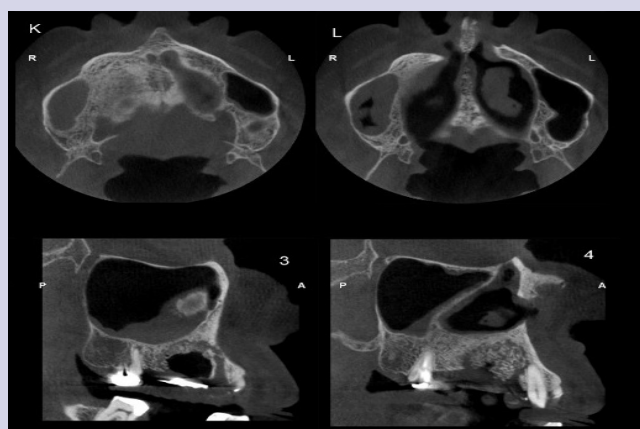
CT showing maxillary MRONJ five months after the start of treatment.
